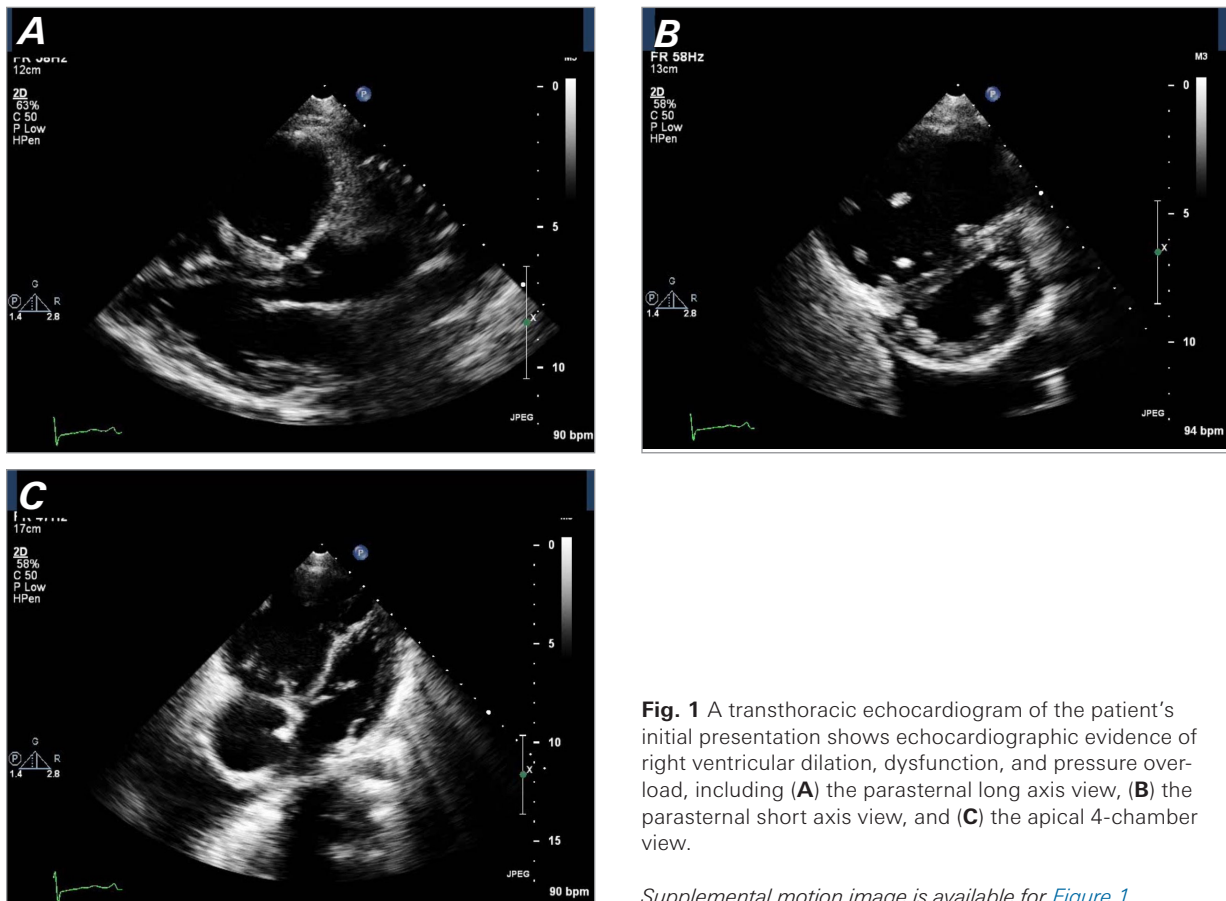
A transthoracic echocardiogram of the patient's initial presentation shows echocardiographic evidence of right ventricular dilation, dysfunction, and pressure overload, including (A) the parasternal long axis view, (B) the parasternal short axis view, and (C) the apical 4-chamber view.
